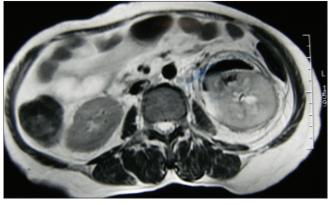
MRI showing gas in the perinephric space (Class IIIA EPN)
